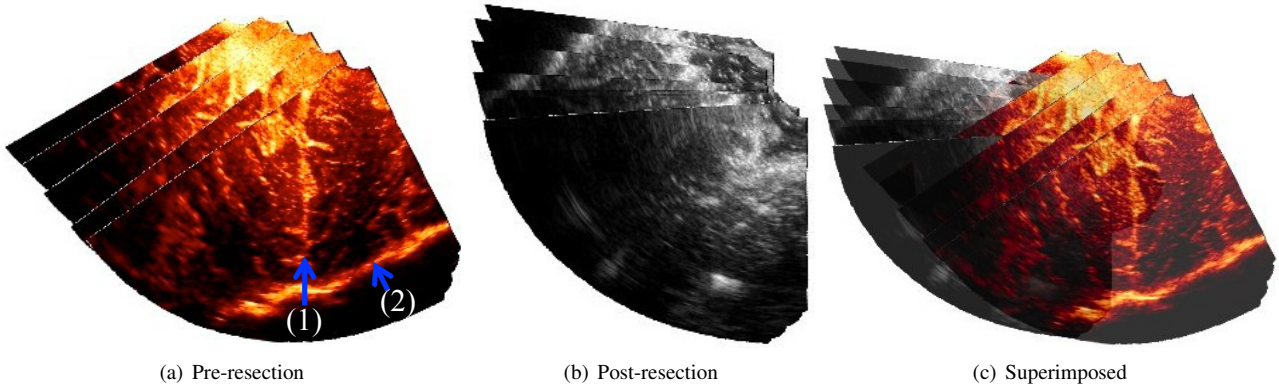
The ultrasound 2D images acquired before and after the resection of the tumor. (1) and (2) are respectively the longitudinal cerebral fissure and the skull. More than 200 images are acquired in each sweep; we are showing just a few here for improved visualization.
